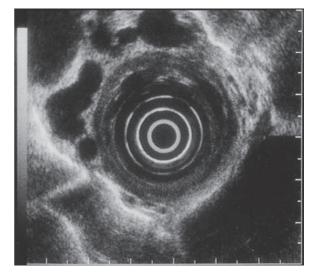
Endosonographic appearance of periesophageal varices
